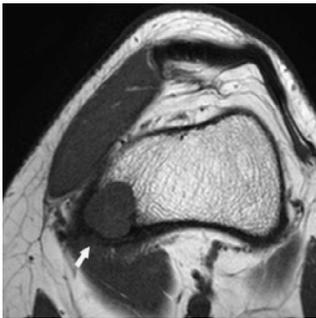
An axial view of a T1-weighted image shows an area of low signal intensity (arrow).
